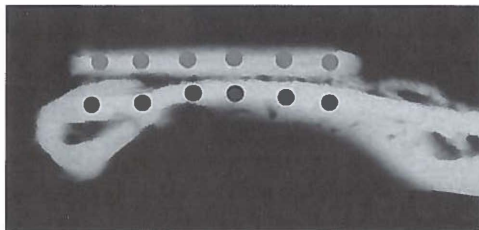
Preparation of samples and transversal microradiography. Post mortem 3 cuts were made in the transversal plane through the center of the graft, located at the left mandibular angle, to create 2 cross-sections (1. and 2.) With an X-ray source transversal microradiographs were taken on film. After film development the images were magnified and digitized.
